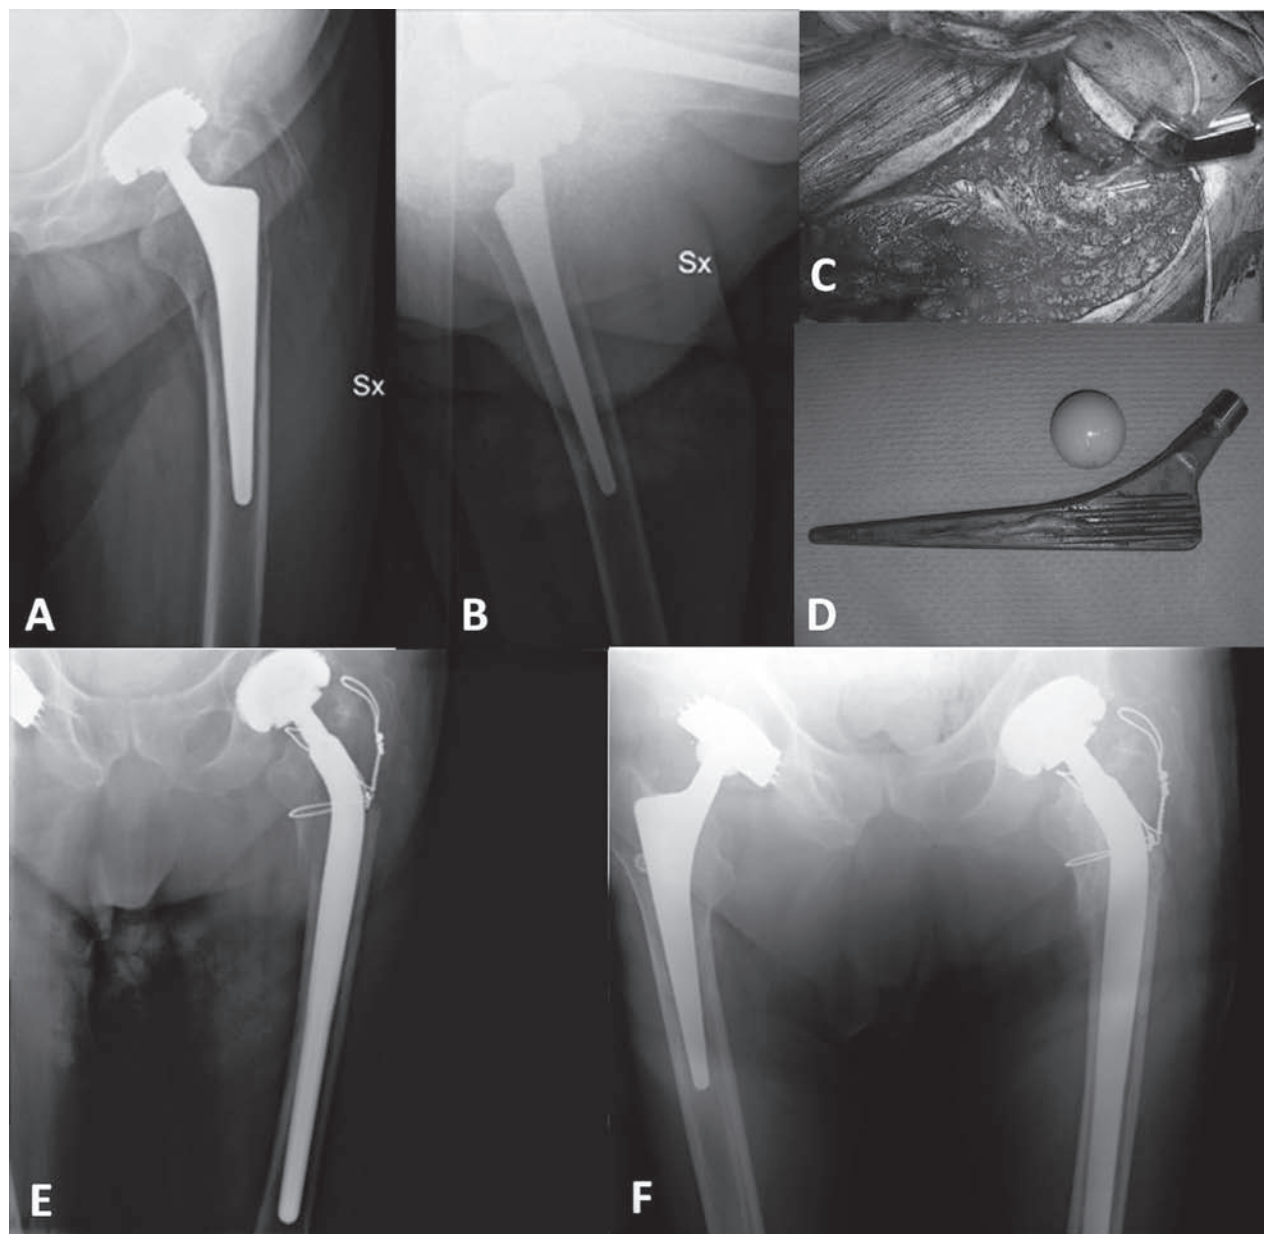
Left periprosthetic fracture which was initially treated as type B1. A and B; preoperative x-ray. C and D; intraoperative views which demonstrated stem instability. E; postoperative x-ray after revision of the stem and positioning of labels. F; x-ray 28 months after trauma with fracture consolidated.
